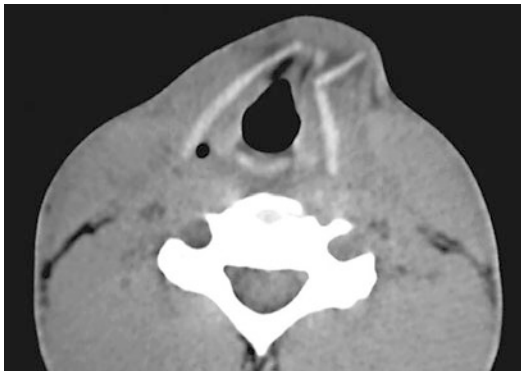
CT image of a patient with paramedian fracture of the thyroid cartilage. A fragment of cartilage is displaced laterally. The airway appears to be patent
